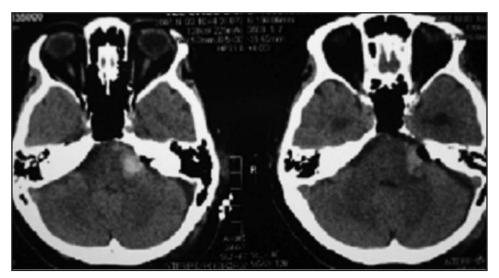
CT brain post operative day one shows a small haematoma(1 cm) at the tumour bed.
